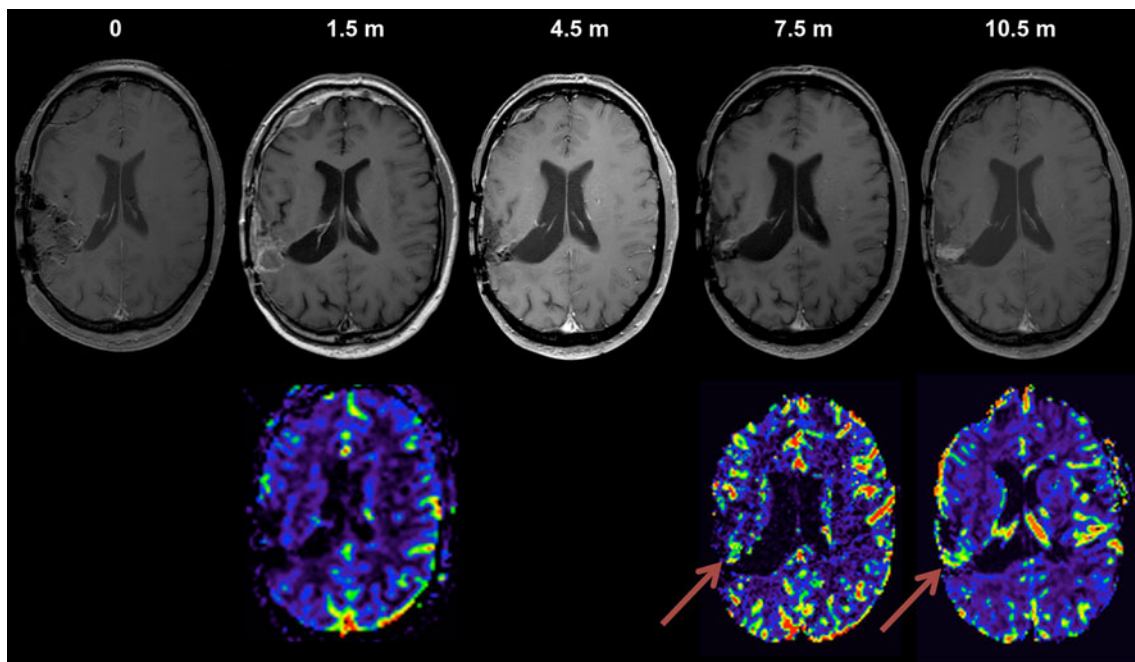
Progressive-tumour patient (patient 7). T1-weighted post-contrast images and rCBV maps at different time points in the follow-up. Time points in months. *0*—post-operatively, 25 days before the start of immune therapy. *1.5 m*—1.5 months after the start of immune therapy; patchy contrast enhancement with some more linear enhancement of the resection cavity. *4.5 m*—minimal residual enhancement in the medial border of the resection cavity and a small increase in contrast enhancement in the latero-superior part (not
